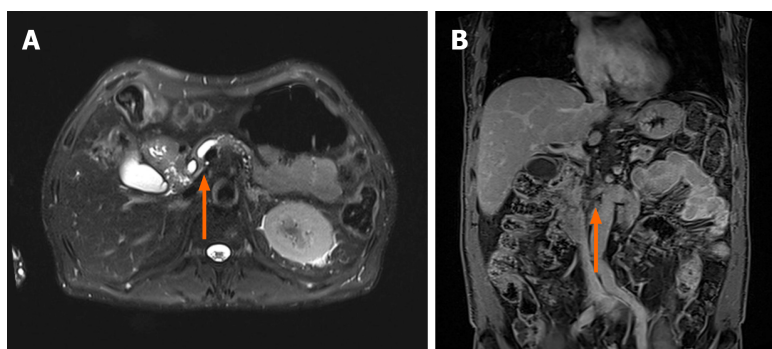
Magnetic resonance imaging. A: An ill-defined space-occupying lesion invading the distal common bile duct and main pancreatic duct, both of which were narrowed, and the upstream main pancreatic duct dilated (orange arrow); B: The lesion severely encased the superior mesenteric artery (orange arrow).
